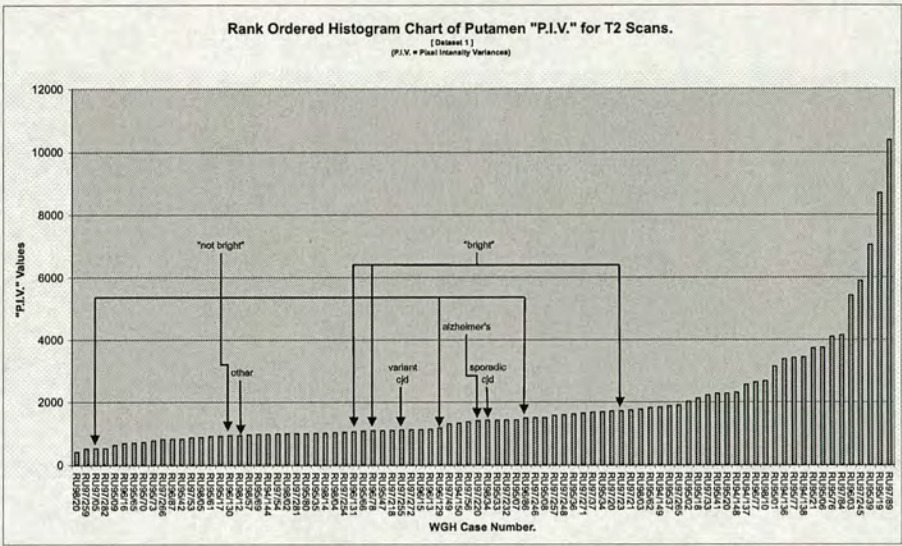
Blind Testing: Rank ordered histogram chart of the Putamen region "P.I.V" values for the T2 weighted MRI scan-data from datasets 1 with the example cases identified by the data-key holder and the expert observer highlighted.
